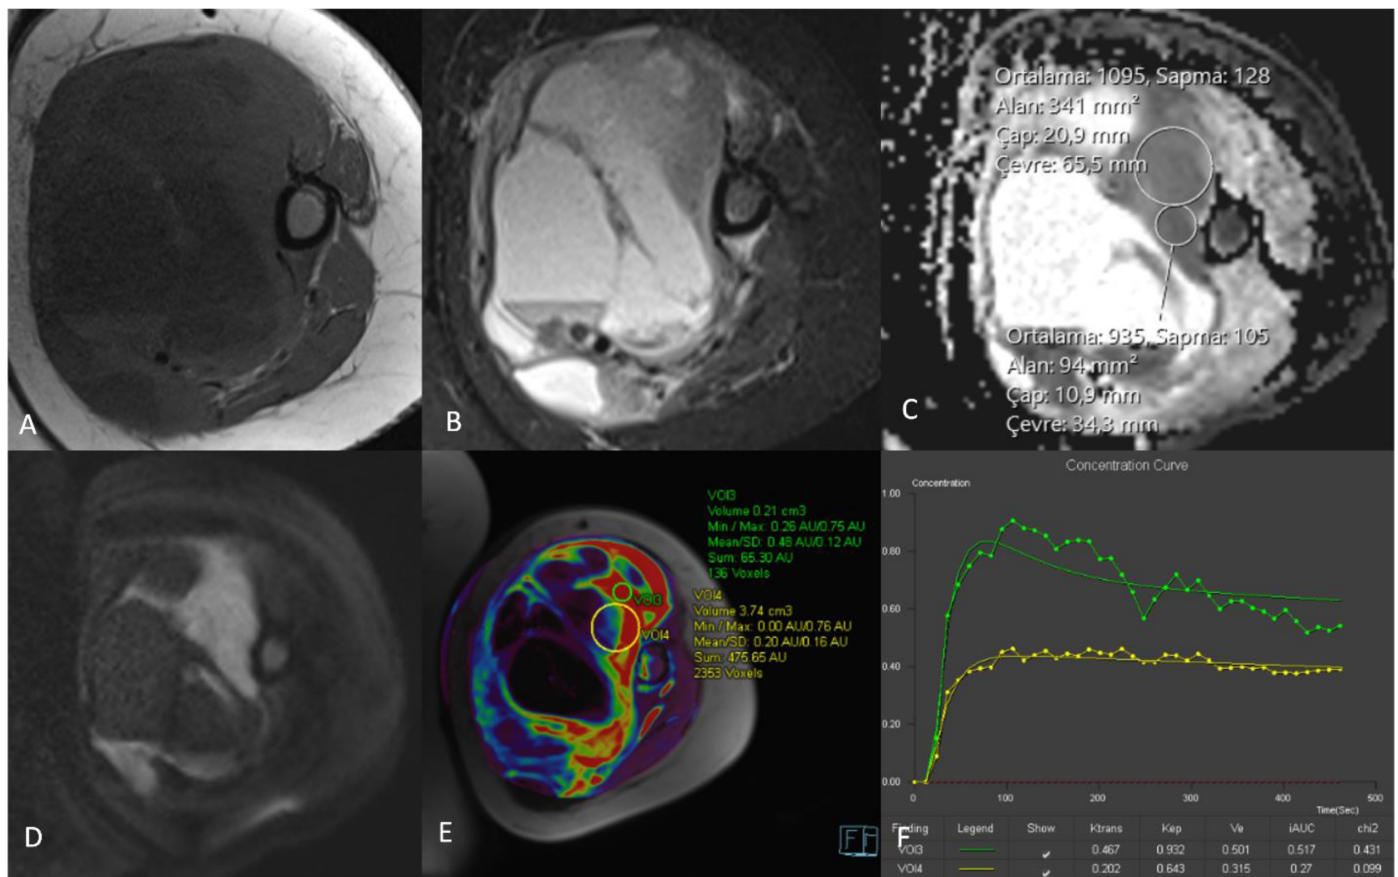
A 56-year-old male patient with undifferentiated pleomorphic sarcoma (grade 3) of the left thigh. A: axial T1WI. B: axial FS T2WI. C and D: ADC map, DWI images (b800). E and F: Ktrans map and dynamic curves.
